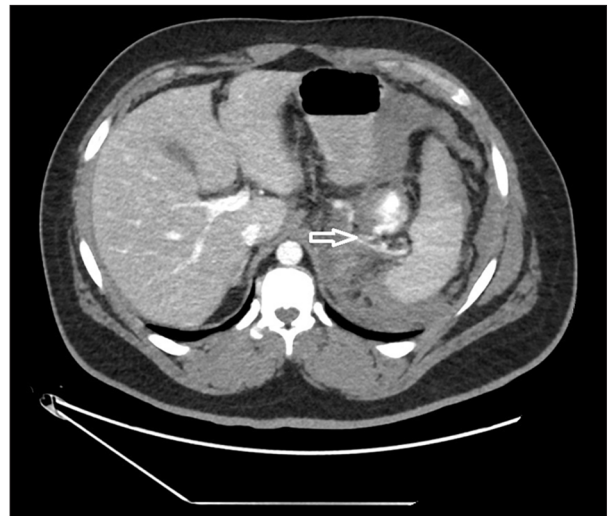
Abdominal CT scan with IV contrast showing a thin neck connecting the splenic artery and the aneurysm.
